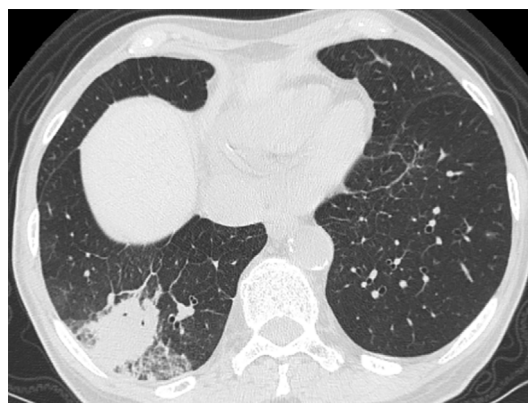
Non-contrast CT in the lungs on the third admission. Infiltrative shadow was observed in the right inferior lobe.
